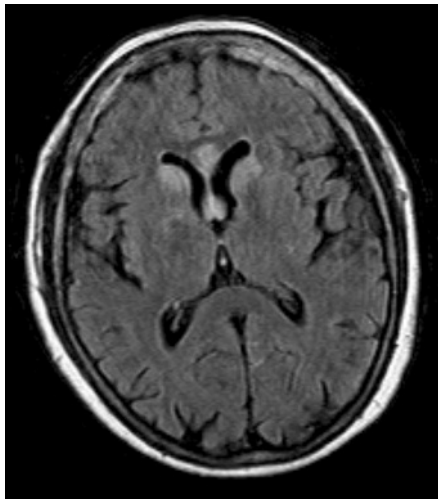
Axial FLAIR MR image shows bilateral high signal intensity of the head of the caudate nuclei, the genu of the corpus callosum and the fornices, consistent with acute infarction.
